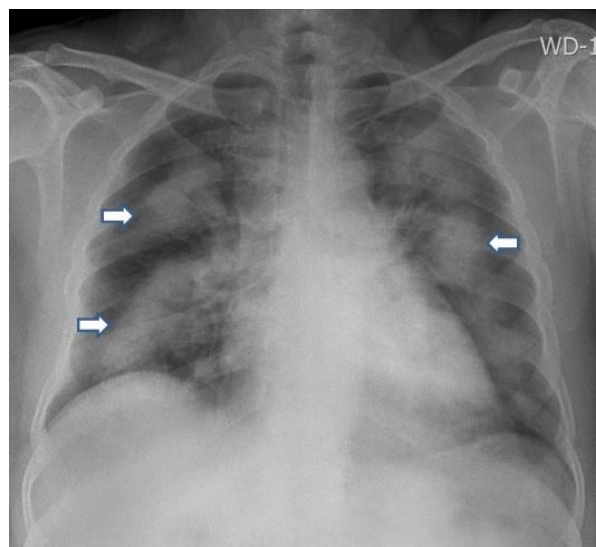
AP chest radiograph reveals ground glass densities in bilateral upper and mid zones (thin arrows) and areas of consolidations involving left bilateral lower zones (thick arrows) in central as well as peripheral distribution.
